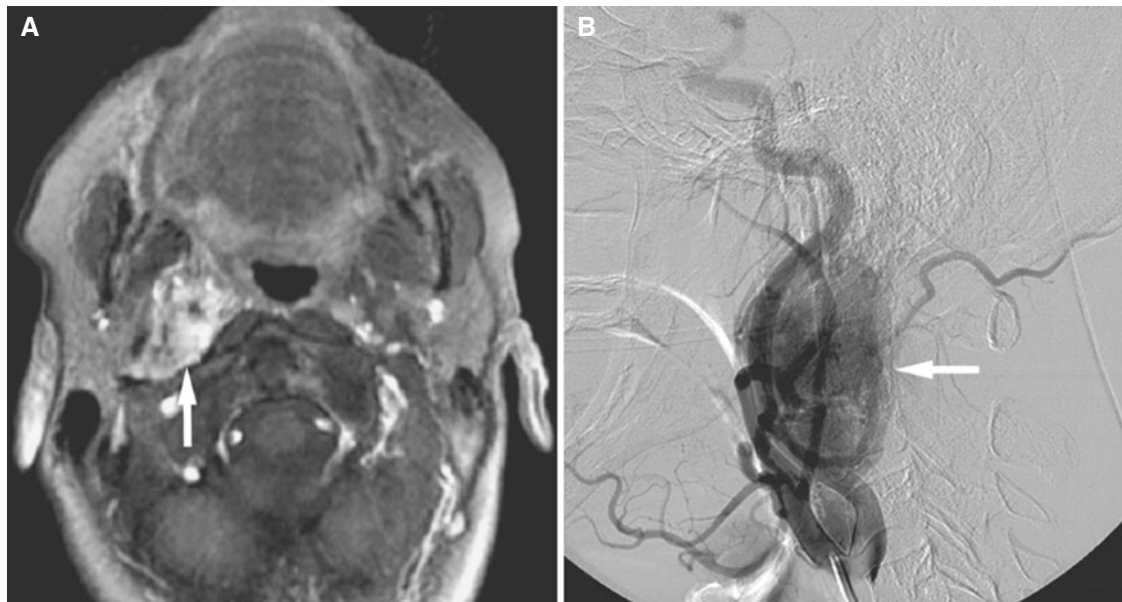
Glomus vagale paraganglioma; 54-year-old female with symptoms of dysphagia. There was a palpable mass on the right side of the neck. (A) Axial T1-weighted post-Gd MRI demonstrates enhancing
